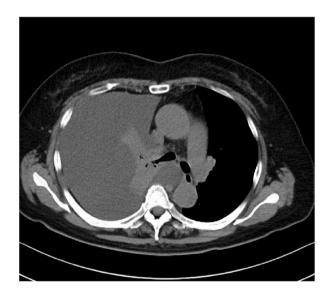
CT at the first visit.
